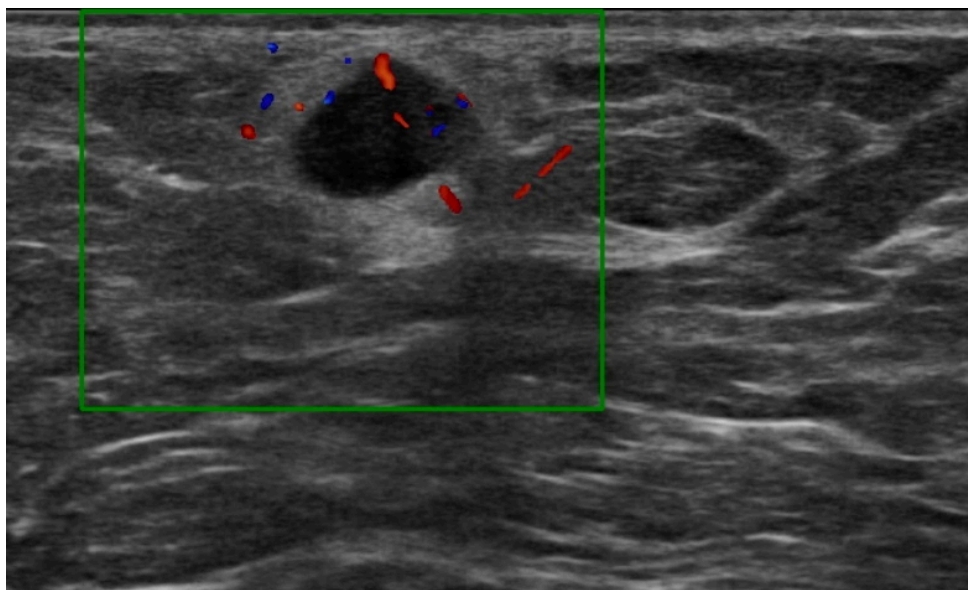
Ultrasound of an axillary lymph node with absence of fat hilum, round shape, abnormal L/T ratio and mild perinodal oedema, metastasis was confirmed.
